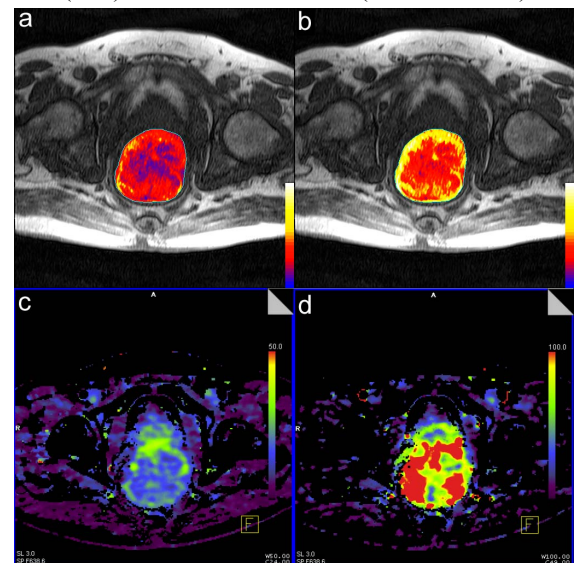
K^{trans} (0-1min⁻¹) b) AUGC₆₀ (0-50mmol.s) parametric overlays on MR images of a T4 rectal tumour; c) FE (0-50ml.100ml⁻¹.min⁻¹) and d) rBF (0-100 ml.100ml⁻¹.min⁻¹) parametric DCE-CT images of the same tumour.
